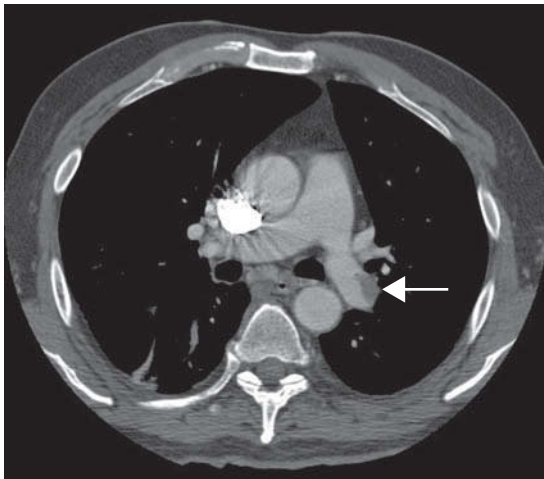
Axial CT section through the thorax following intravenous contrast, showing a large thrombus within the left main pulmonary artery. Courtesy: S.V. Mahadevan, MD.
